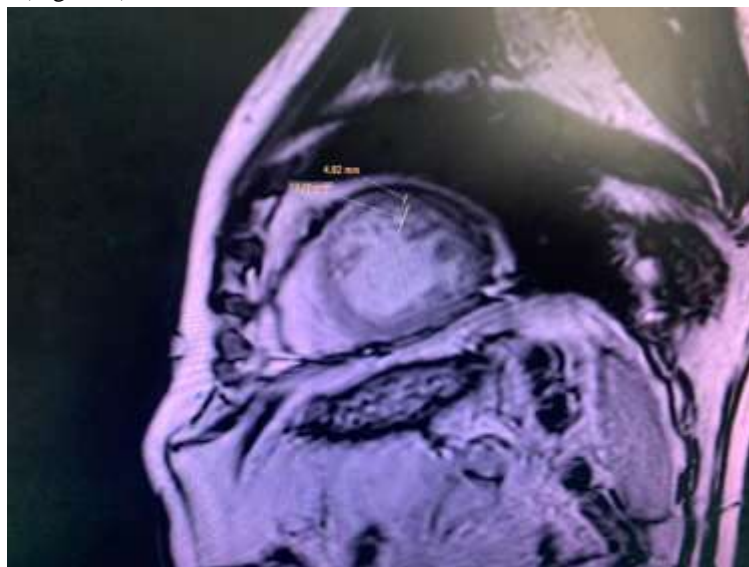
Cardiac MRI in short-axis view showing the left ventricular trabeculations.
